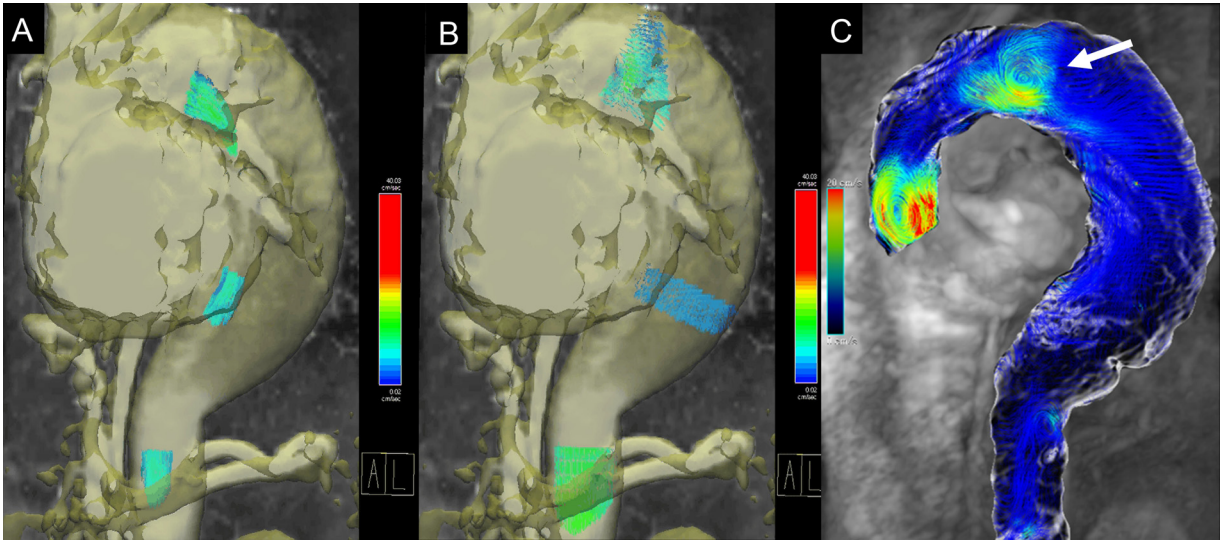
Oblique sagittal pathline images in the TL (A) and FL (B), and a streamline image (C) obtained from 4D flow MRI. The images (A, B) revealed that the average net flow in the TL and FL were 7.1 and 65.8 mL/sec, respectively. The streamline image (C) demonstrated a large vortex flow and retrograde flow in the proximal part of the FL of the descending aorta (white arrow).
